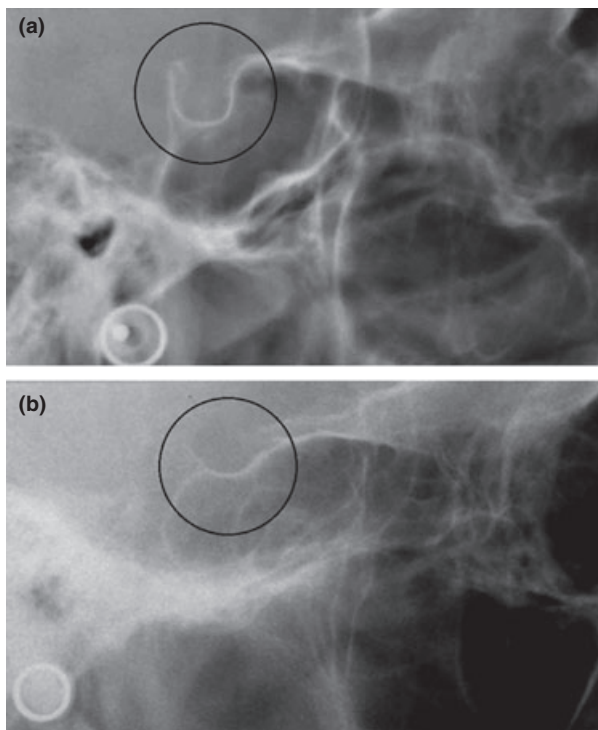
Lateral radiograph of sella turcica (a) and normal morphology (b). Abnormal morphology with diverging anterior and posterior walls in a patient with myelomeningocele.
